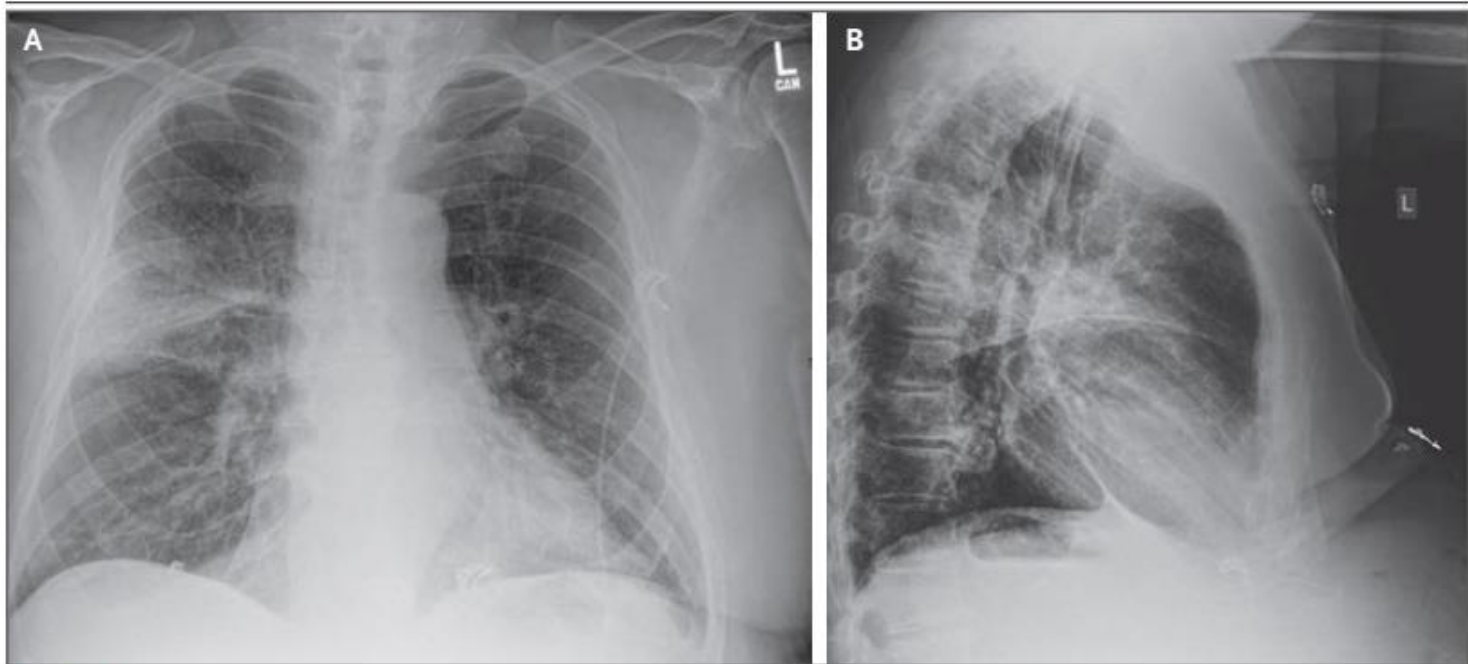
Chest Radiographs.
